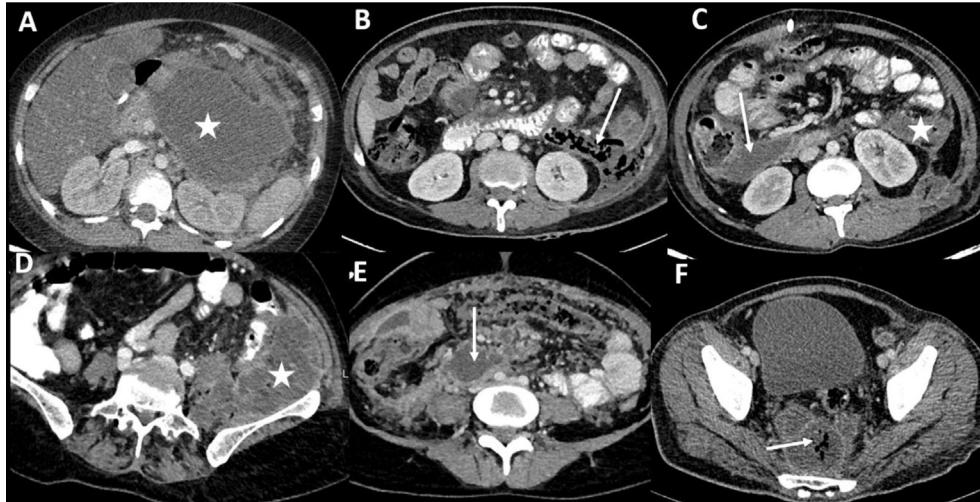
Sites of EPN on contrast enhanced CT scan in different patients. A. A large collection is seen in the lesser sac (star). B. There is a collection in the left anterior and posterior pararenal space (arrow). C. A collection is seen in the right anterior pararenal space (star). Also note a collection in left anterior pararenal space (arrow). D. A large left paracolic gutter collection is seen (star). E. There is a collection in the mesentery (arrow). F. A collection is seen in the pelvis (arrow).
